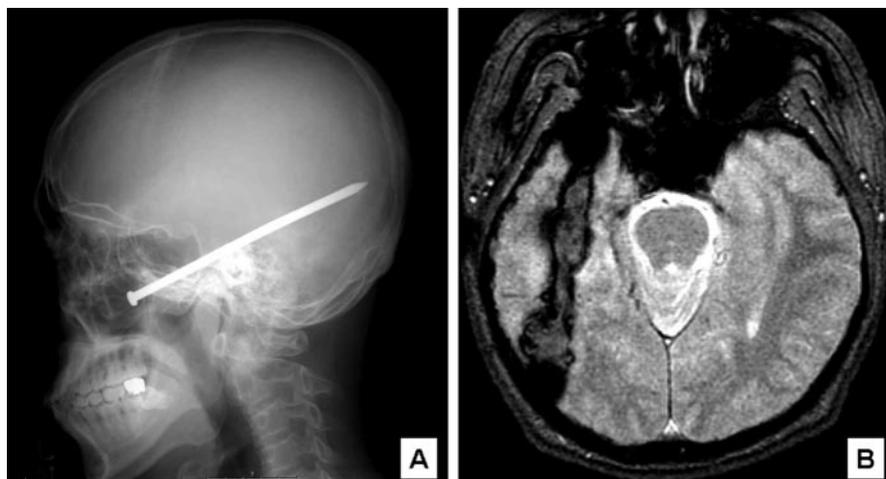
(A) Preoperative lateral plain skull x-ray shows the nail. (B) Postoperative angulated axial gradient-echo MRI reveals hemorrhagic tract.
